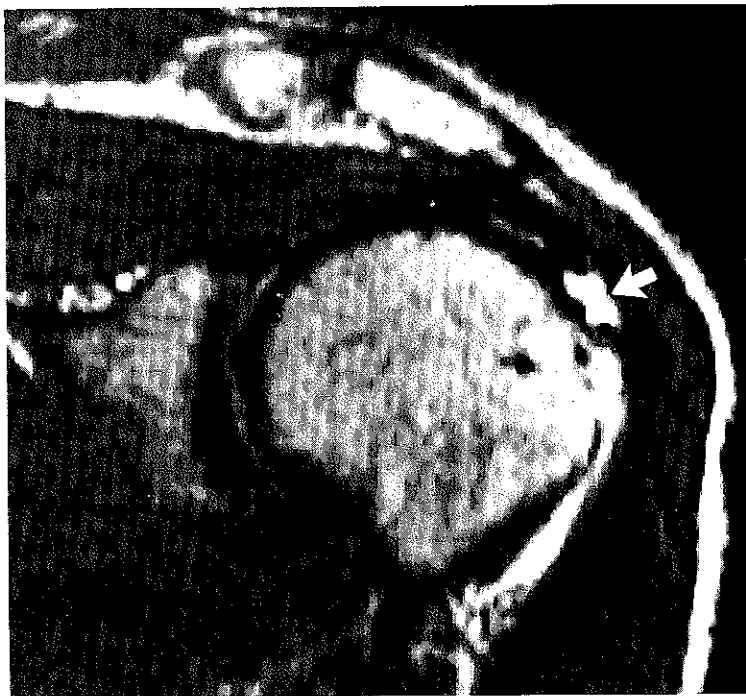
Supraspinatus tendon tear. T2-weighted image (SE 2000/80). The high signal intensity at the tendon insertion represents fluid (arrow).
